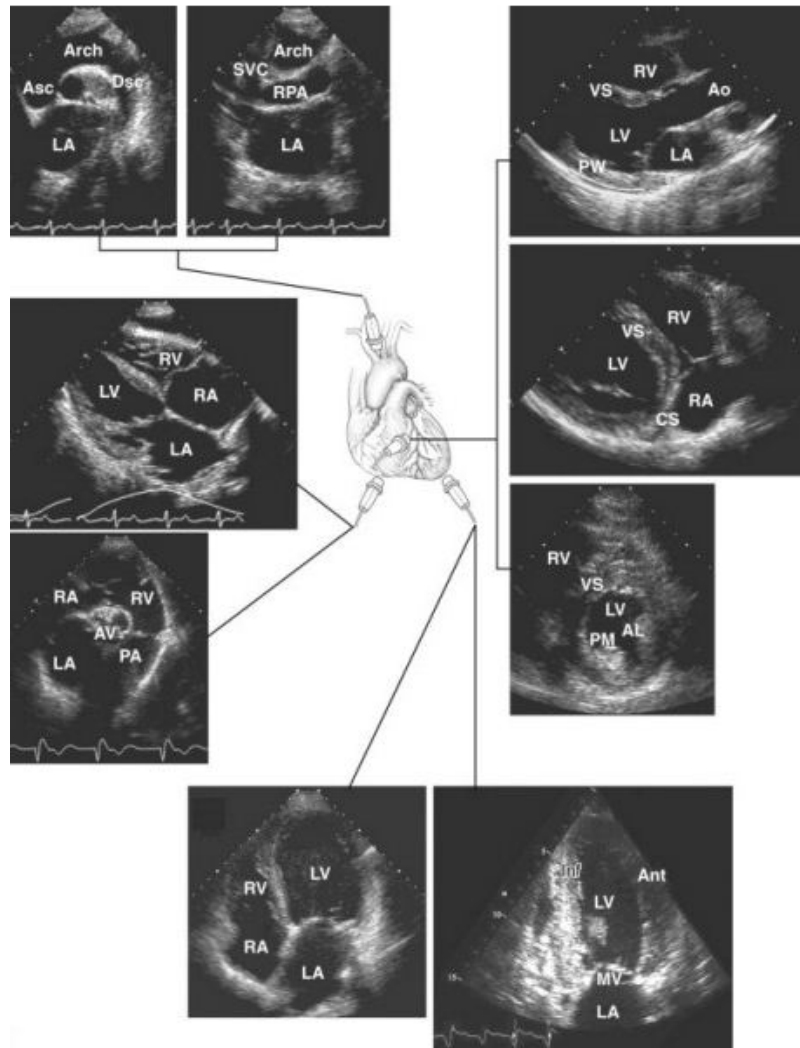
VARIOUS TOMOGRAPHIC ECHOCARDIOGRAPHIC IMAGES ^[69]
